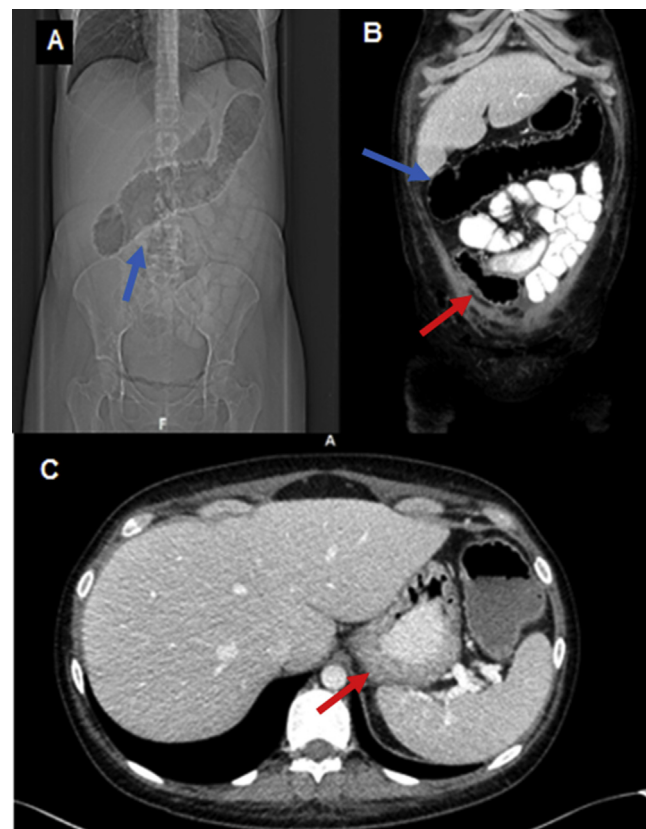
CT scan showing large bowel distention (blue arrows) (A, B) and significant wall thickening (red arrows) (B, C).
